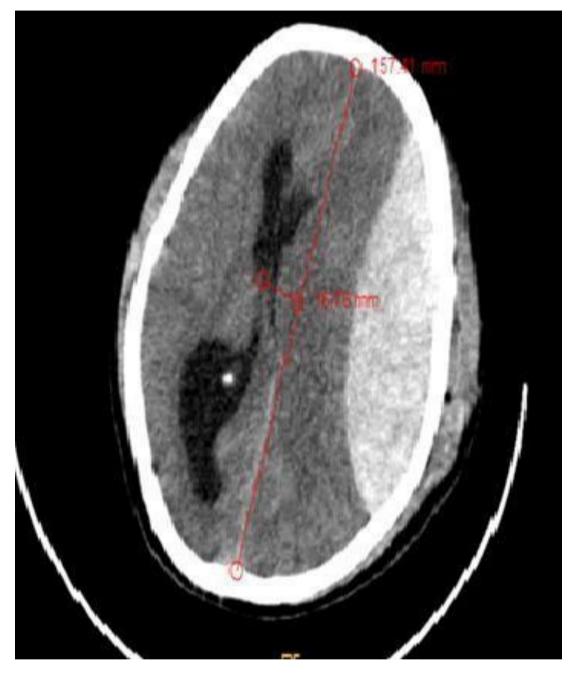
Axial non contrast enhanced brain CT showing a large EDH in the left frontoparieto-temporal lobe causing mass effect over ipsilateral lateral ventricle and midline shift of 18.7 mm to right
